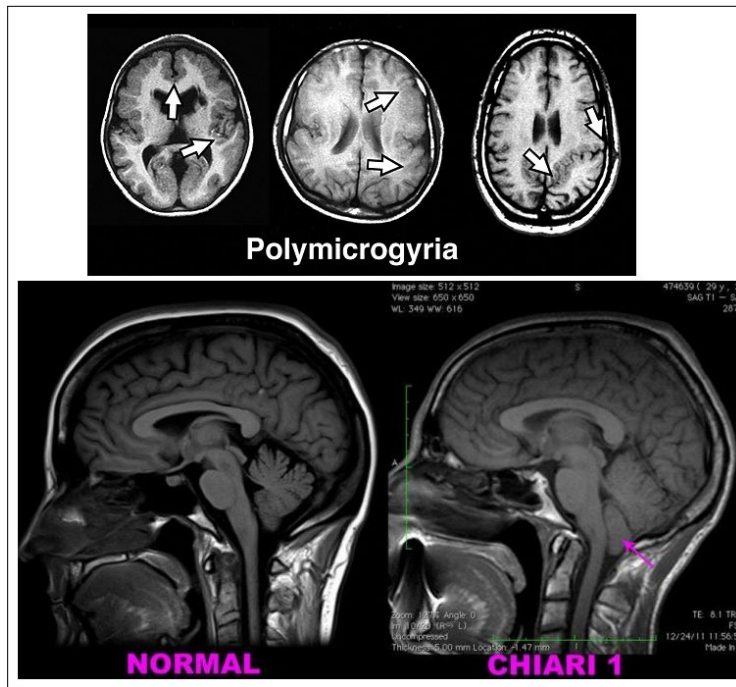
Radiographic images of cerebral malformations of polymicrogyria and chiari versus normal brain.
